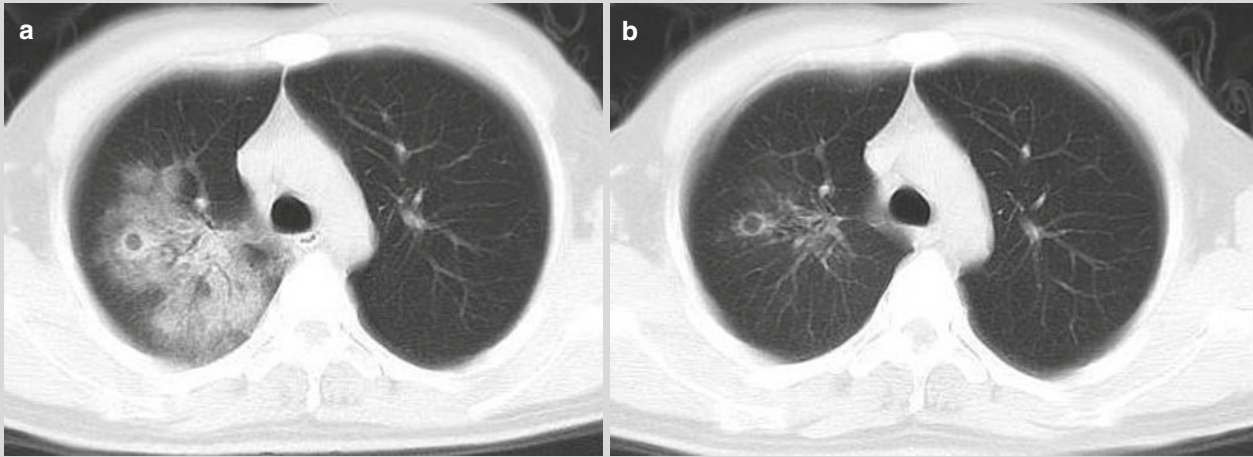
CT scan showed flakes of poorly defined opacity in the right upper lung lobe, with bronchi sign and thick-wall translucent opacity (a); Reexamination after treatment showed thin-wall translucent opacity (b)
